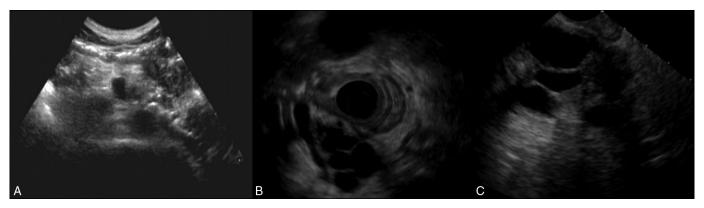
(A) Transabdominal ultrasound revealing a solid-cystic mass at the pancreatic head. (B) Endoscopic ultrasound indicating a 29.9 imes 32.7-mm nonhomogeneous hypoechoic solid-cystic mass detected at the pancreatic head. (C) Network structure and hypoechoic nodules.
